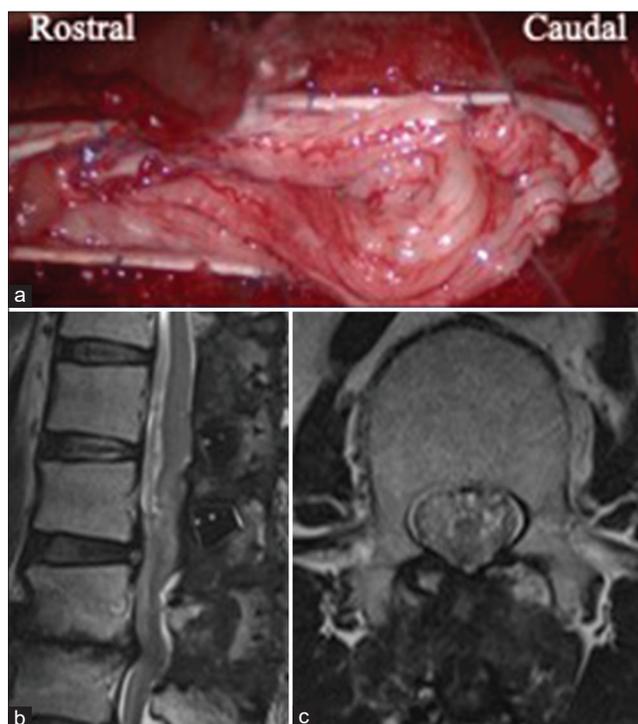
A still image from the operative video shows congested and swollen cauda equina herniating out from the dural opening. Duraplasty with a Gore-Tex membrane was required to close the dura (a). Postoperative T2-weighted sagittal (b) and axial (c) images of the lumbar spine show disappearance of the hyperintense mass lesion.
